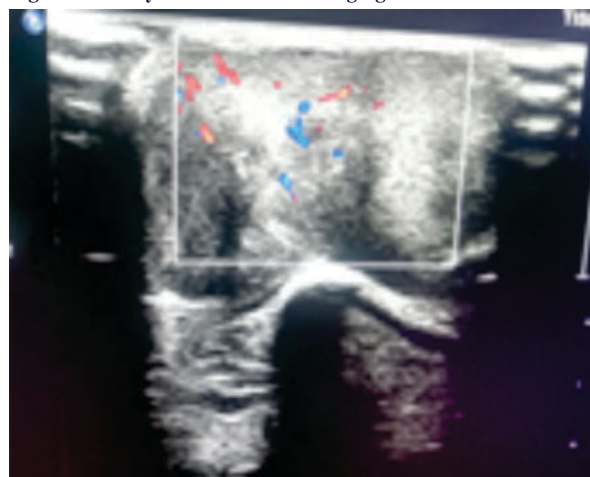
On Colour Doppler Study, The Mass Showed Internal Vascularity
